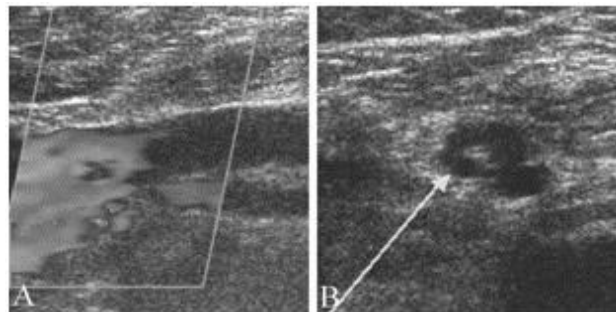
Deep venous thrombus in a 61 year old man with leg swelling and pain. A. Sagittal Doppler ultrasound study shows lack of filling in the distal femoral vein. B. Axial ultrasound study shows a filling defect within the lumen of the popliteal vein (arrow).
